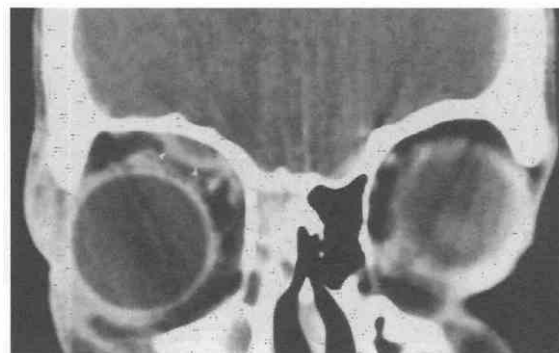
CT scan shows subperiosteal abscess of the superior orbit (arrowheads) from ethmoid or frontal sinus disease.
